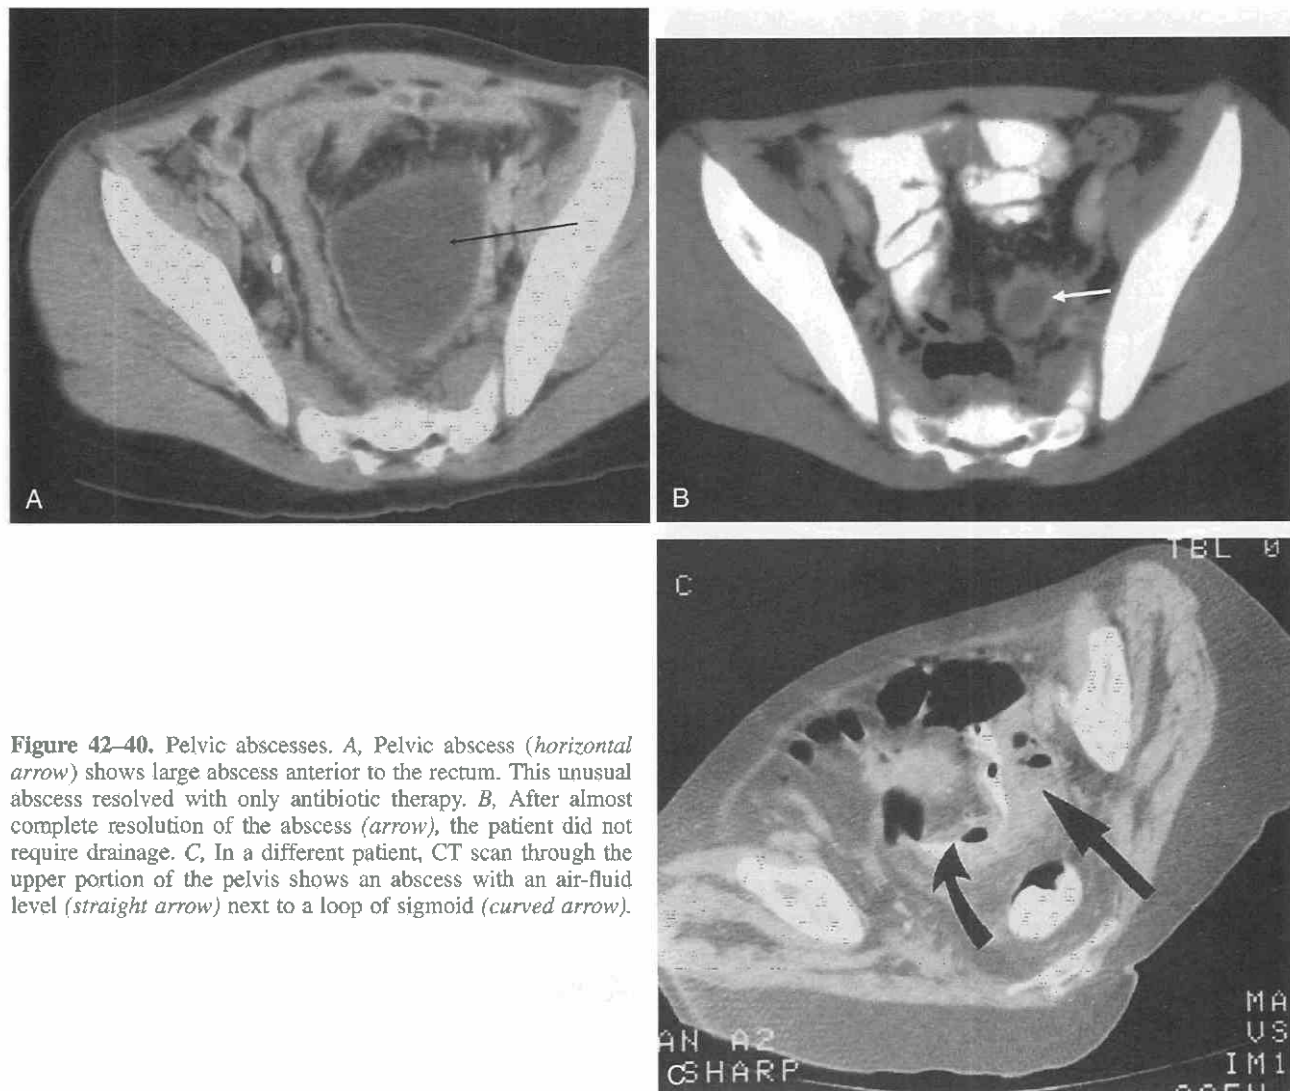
Pelvic abscesses. *A*, Pelvic abscess (*horizontal arrow*) shows large abscess anterior to the rectum. This unusual abscess resolved with only antibiotic therapy. *B*, After almost complete resolution of the abscess (*arrow*), the patient did not require drainage. *C*, In a different patient, CT scan through the upper portion of the pelvis shows an abscess with an air-fluid level (*straight arrow*) next to a loop of sigmoid (*curved arrow*).
